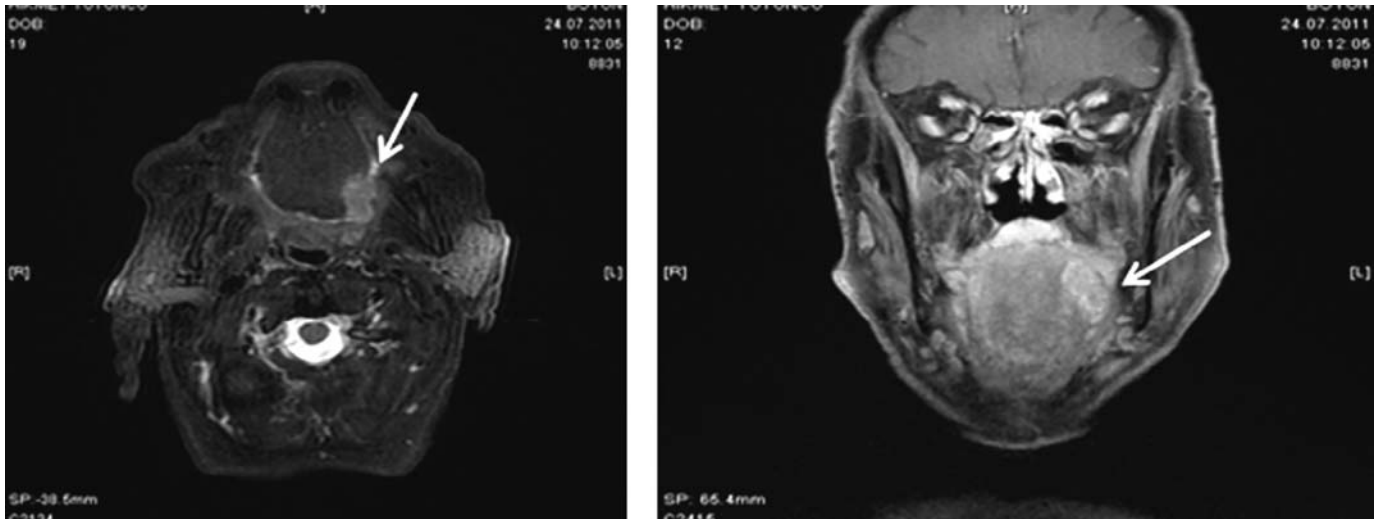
The magnetic resonance imaging of the lesion that was marked by a white arrow.
